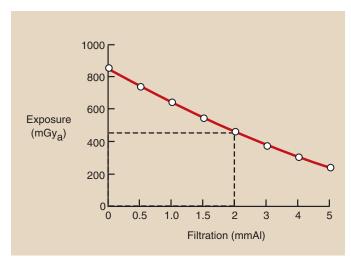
Measurement of x-ray beam intensity as a function of added filtration results in a half-value layer (HVL) of 2.0 mm Al.
